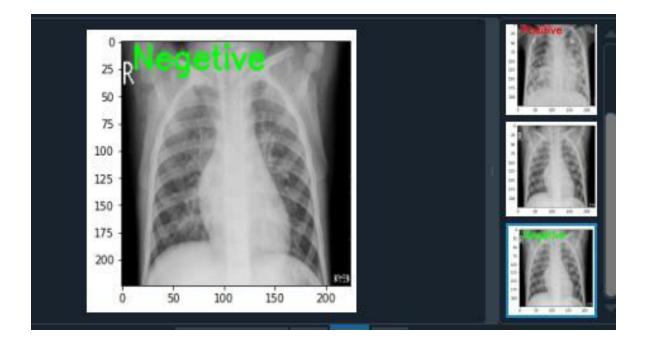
testing –Xray images (Negative)
